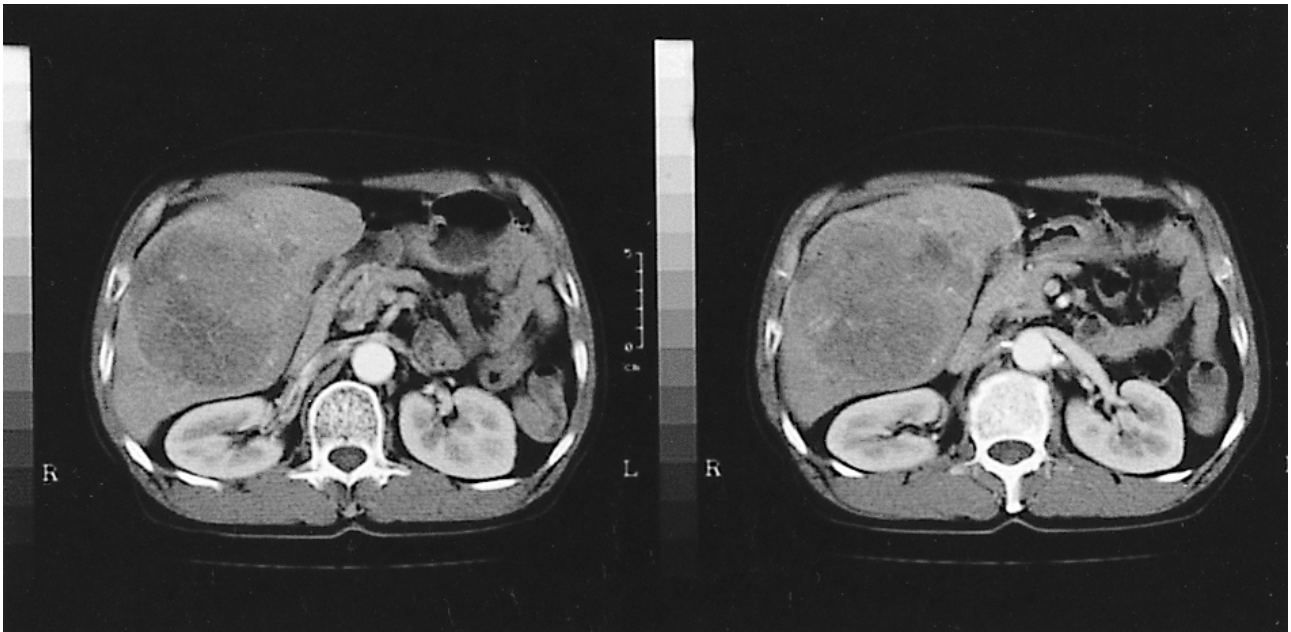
Computed tomography showing a huge hepatic mass on arterial phase.
